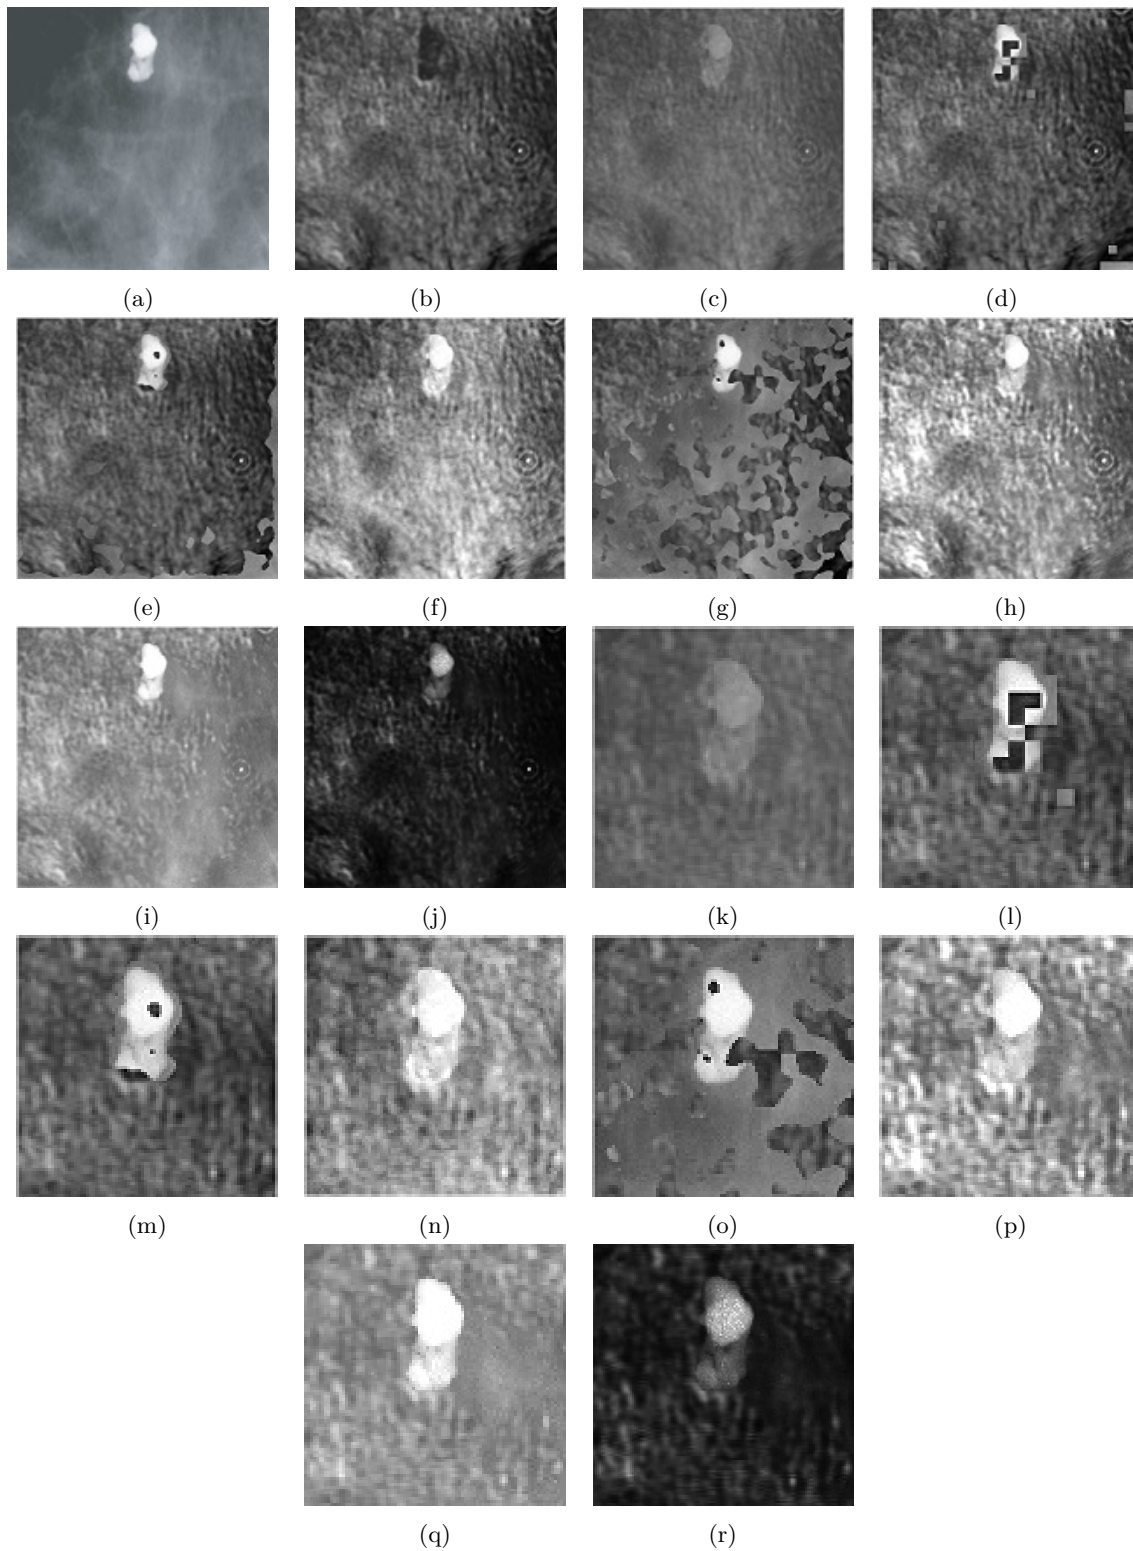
Fusion results for X-ray and VA images. (A) X-ray image (B) VA image (C) Fused image by simple average (D) Fused image by DCT (E) Fused image by RWT (F) Fused image by Intuitionistic fuzzy set (G) Fused image by Fuzzy transform (H) Fused image by proposed method (I) Fused image by Interval-valued intuitionistic fuzzy set (J) Fused image using Yue Entropy [38] (K), (L), (M), (N), (O), (P), (Q), (R) are the magnified results of (C), (D), (E), (F), (G), (H), (I) and (J) respectively.
